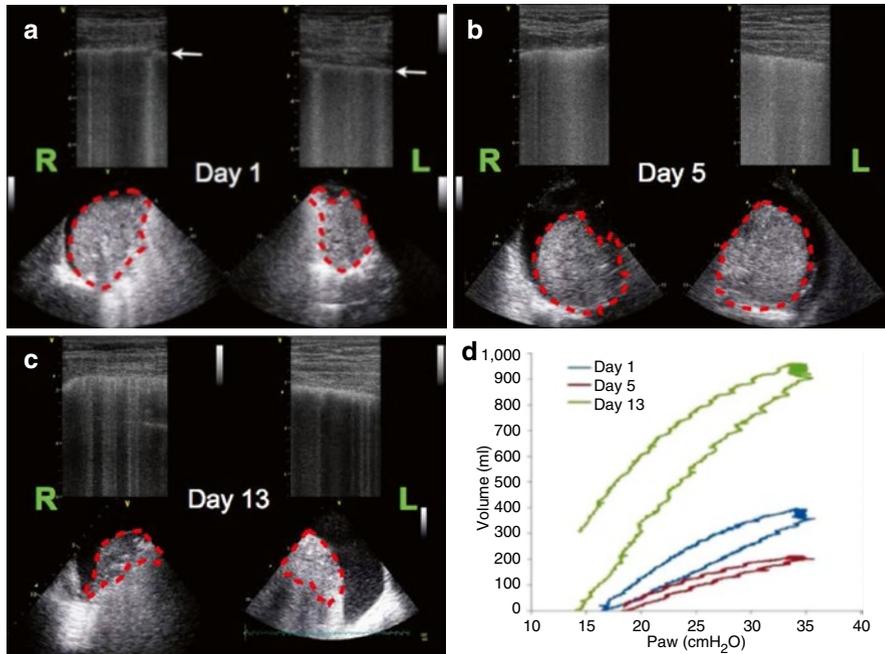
Monitoring of VV ECMO-assisted ARDS varicella pneumonia patient by means of lung ultrasound. (a–c) Quad panels show LUS changes over time in representative ventral (*upper pictures* of each quad panel) and dorsal (*lower pictures* of each quad panel) areas of the lung (transversal scans through the same intercostal spaces, respectively, in the most nondependent and dependent areas, on both lungs; *R* right, *L* left). Panel (d) shows P–V curves performed simultaneously to LUS images acquisition. All observations performed on day 1, day 5, and day 13 of ICU stay (ARDS onset occurred 2 days before ICU admission). Panel (a) (day 1): ventral areas show a typical sonographic interstitial syndrome pattern with multiple longitudinal artifacts (B lines) arising from the pleural line (horizontal hyperechoic line, *arrow*) and spreading to the edge of the screen; zones of major crowding, especially on the left scan, can be observed; additional features are represented by pleural thickenings and irregularities and scattered subpleural consolidations (all consistent with an inflammatory origin of the edema). Dorsal areas show complete “hepatization” of the lung, i.e., an LUS pattern of consolidation consistent with complete loss of aeration of the most dependent regions (*dashed areas* highlight the extension of these consolidations). The corresponding P–V curve in panel (d) shows a very low compliance ($C_{pl_{RS}}=20$ ml/cmH₂O) and a limited recruitability, as demonstrated by the small hysteresis of the curve. Panel (b) (day 5): ventral areas now show an increase in B lines crowding, even reaching on the left scan the pattern of “white lung” (complete coalescence). *Dorsal areas* show an increase in the size of consolidations (note the dashed areas size) and the appearance of likely abundant pleural effusions (*black, anechoic, layer* surrounding the consolidated lung). The corresponding P–V curve in panel (d) shows now an even smaller compliance ($C_{pl_{RS}}=13$ ml/cmH₂O) and further reduction of recruitability (very small hysteresis of the curve). Panel (c) (day 13): ventral areas finally show a relevant reduction in the number and crowding of B lines, while dorsal ones show a dramatic reduction in consolidated areas size, despite an increase in the pleural effusion amount (thicker anechoic layer). The corresponding P–V curve in panel (d) confirms the relevant improvement of the lungs, as demonstrated by a markedly increased compliance ($C_{pl_{RS}}=43$ ml/H₂O) and a much higher recruitability (wide hysteresis). Patient was successfully weaned from VV ECMO on day 15
